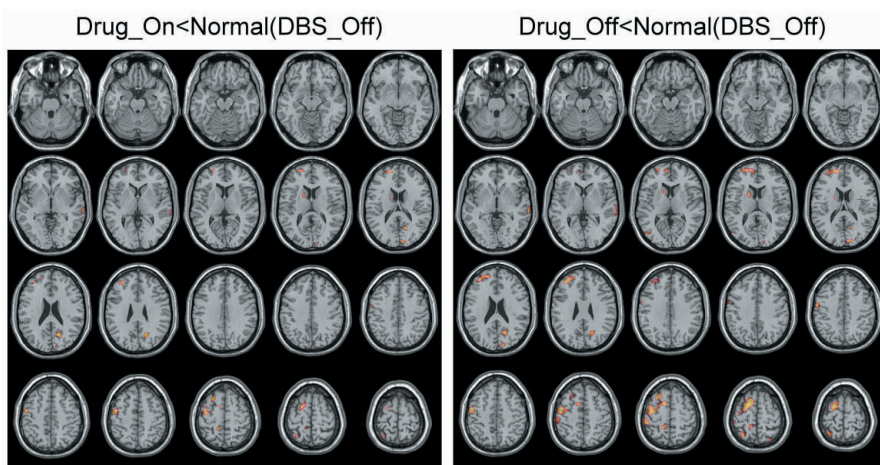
The results of FDG PET/CT during zolpidem ‘on’ (left panel) and ‘off’ phase (right panel).
